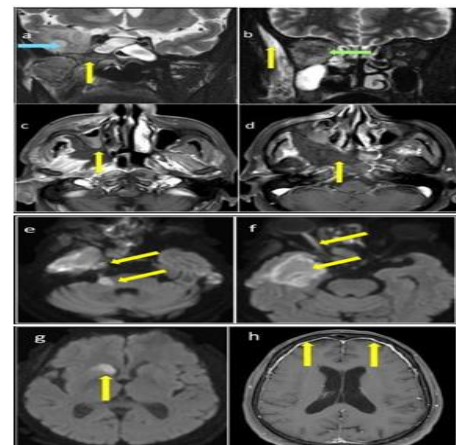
(e,f): Axial DWI in the same patient: restricted diffusion along the course of right trigeminal nerve and infarct in the pons at its root exit zone (yellow arrows in e). Also seen are Rt posterior ischemic optic neuropathy and Rt temporal lobe cerebritis (yellow arrows in f). (g, h) Follow up imaging in the same patient: DWI (g) and T1 post contrast (h) images demonstrate infarct in the right caudate nucleus as a complication and diffuse pachymeningeal enhancement.
